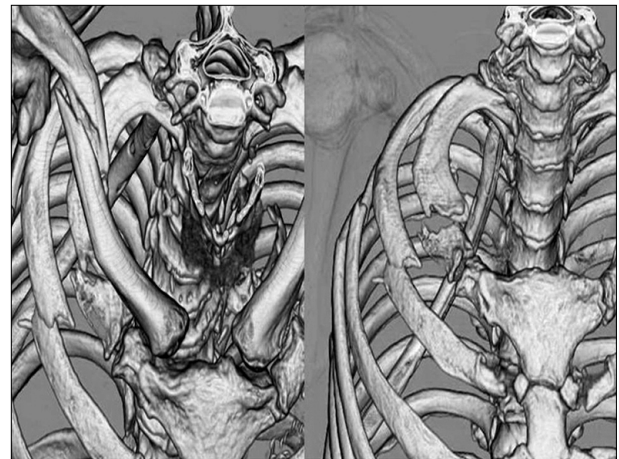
Chest computed tomography with 3-dimensional reconstruction shows right clavicular and multiple rib fractures involving 1st rib.
